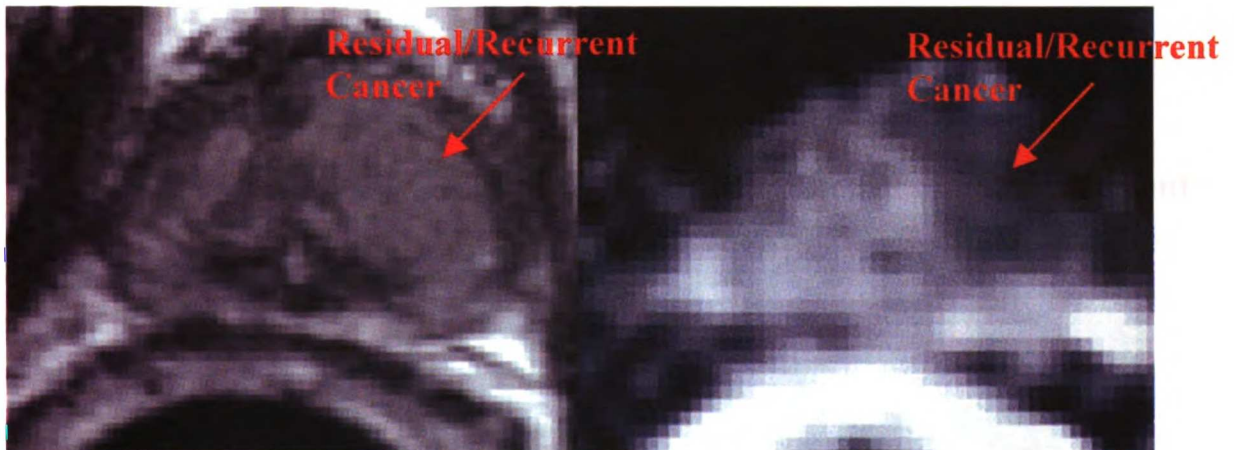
T2-weighted MRI (left) and $\langle D \rangle$ map (right) following hormone ablation therapy. Despite rather uniform T2 appearance, $\langle D \rangle$ is decreased in region of cancer.
